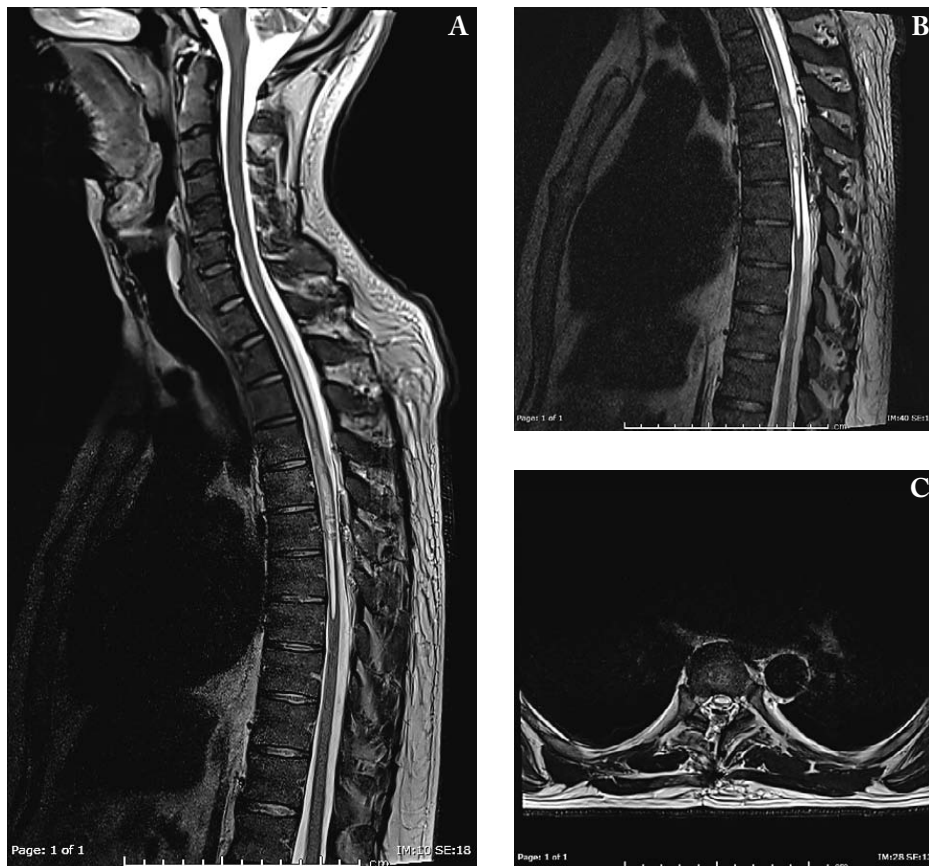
(A) Postoperative sagittal T2-weighted magnetic resonance imaging (MRI) scan (one day after surgery) shows significant decrease in the size of both the syrinx and hydromyelia; (B) sagittal T2-weighted SPACE (sampling perfection with application-optimized contrasts using different flip-angle evolution) image; (C) axial T2-weighted MRI scan at T6 level after hemilaminectomy.
